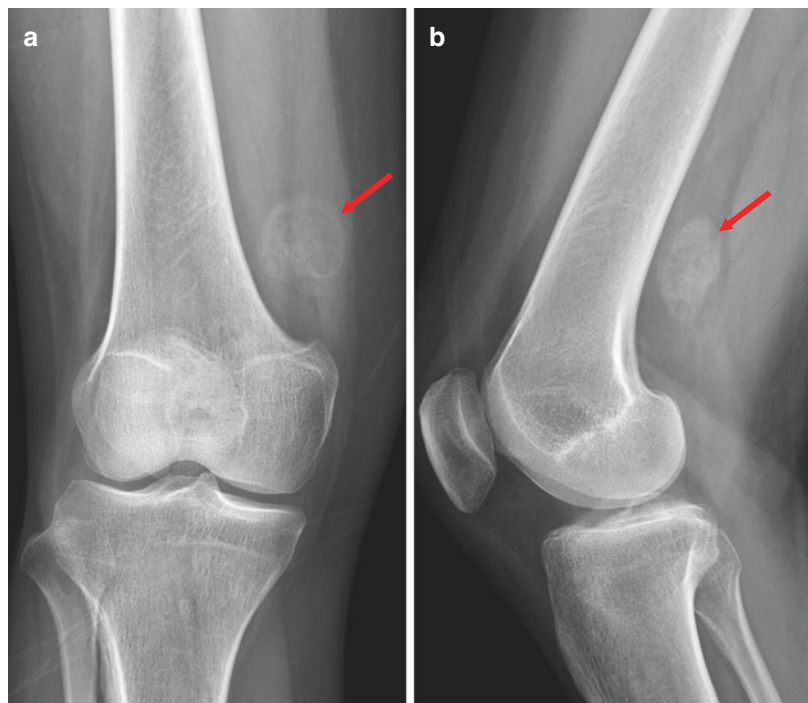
Myositis ossificans. AP (a) and lateral (b) radiographs of the right knee show a mineralized soft tissue mass (arrow) on the posteromedial side of the right distal femur. The mineralization pattern is consistent with myositis ossificans, which exhibits a characteristic zonal phenomenon
